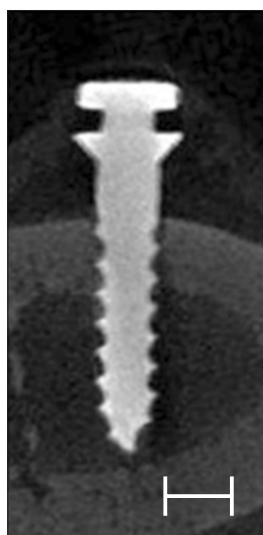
Micro computed tomography image of a miniscrew placed in a laser pre-drilled hole. Scale bar=200 μ m.
